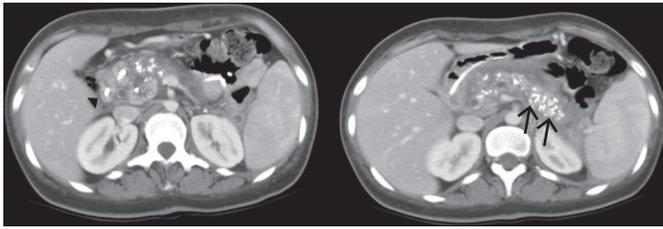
Contrast-enhanced axial computed tomography (CT) imaging from 2004 (age 27) showing intraductal calculi (arrow head) and extensive coarse pancreatic parenchymal calcifications (arrows).
